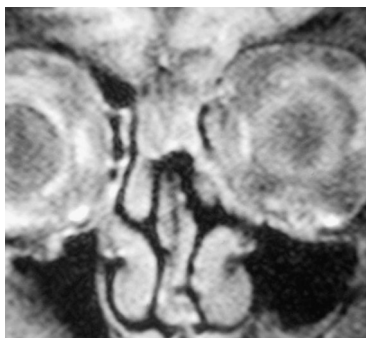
A coronal MRI projection suggesting the possible lack of the cribriform plate and the continued propagation of the tissue, located primarily in the endocranium, into the nasal cavity.
